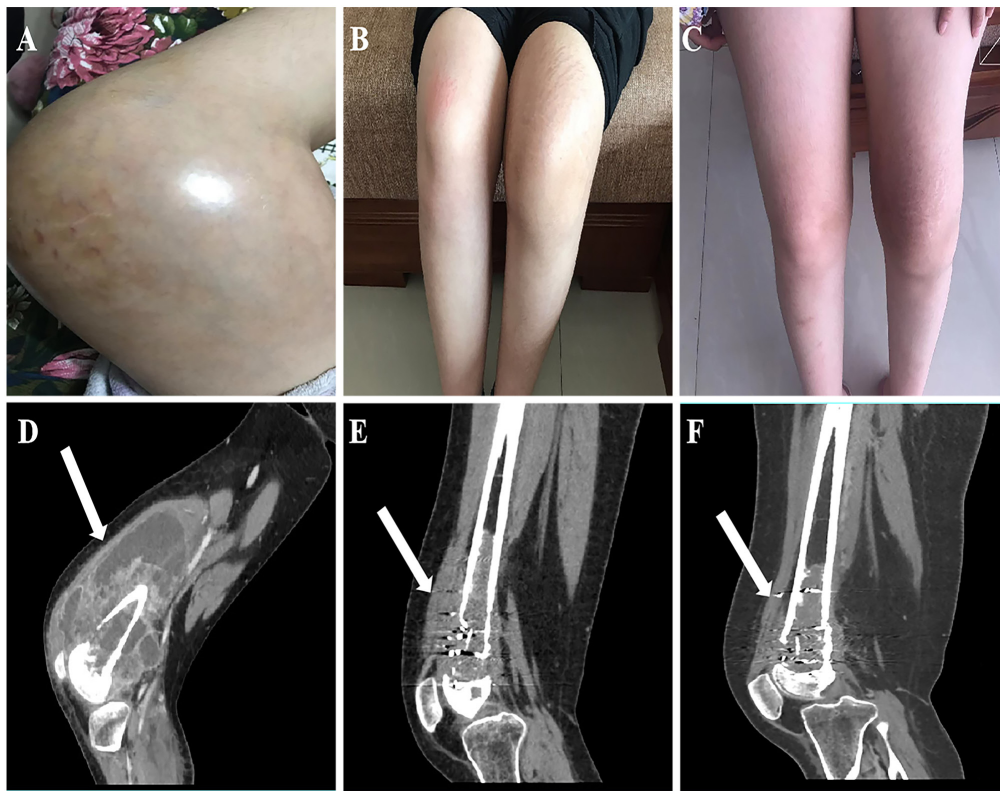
Dynamic changes in the degree of left knee swelling and enhanced CT findings before and after surgery. (A) Preoperatively, the left knee joint exhibited notable swelling and was in a passive flexed position. (B) A total of 6 months post-operation, a partial reduction in swelling of the left knee joint was observed, and (C) a total of 11 months post-operation, further subsidence of swelling in the left knee joint was noted. (D) Preoperative enhanced CT image displayed a large soft tissue mass in the left knee joint, measuring ~12.6 cm in maximum diameter and showing inhomogeneous enhancement. (E) A total of 6 months after the operation, enhanced CT imaging indicated that the mass had decreased, with most tumor tissue having been excised, and (F) a total of 11 months post-operation, enhanced CT imaging revealed a further reduction in mass size.
